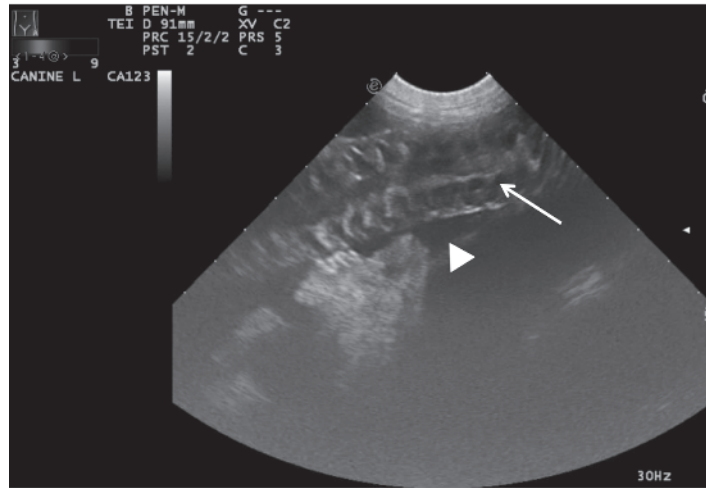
Peritonitis. Ultrasound image of a 5-year-old Coonhound with peritonitis secondary to a uroabdomen. Note the abdominal free fluid (arrowhead) and severe corrugation of the intestinal loop (arrow) (courtesy Dr. Robert O'Brien, DVM, DACVS).
